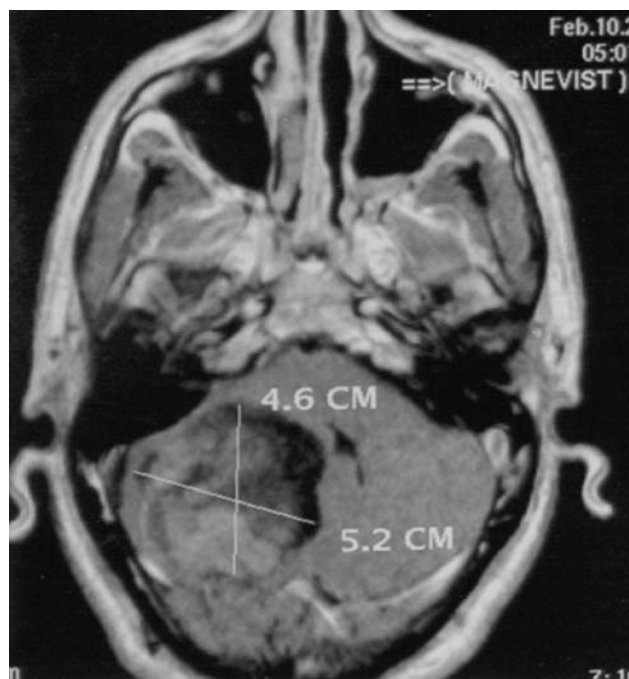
Showing MRI axial cuts of huge posterior fossa desmoplastic medulloblastoma.
